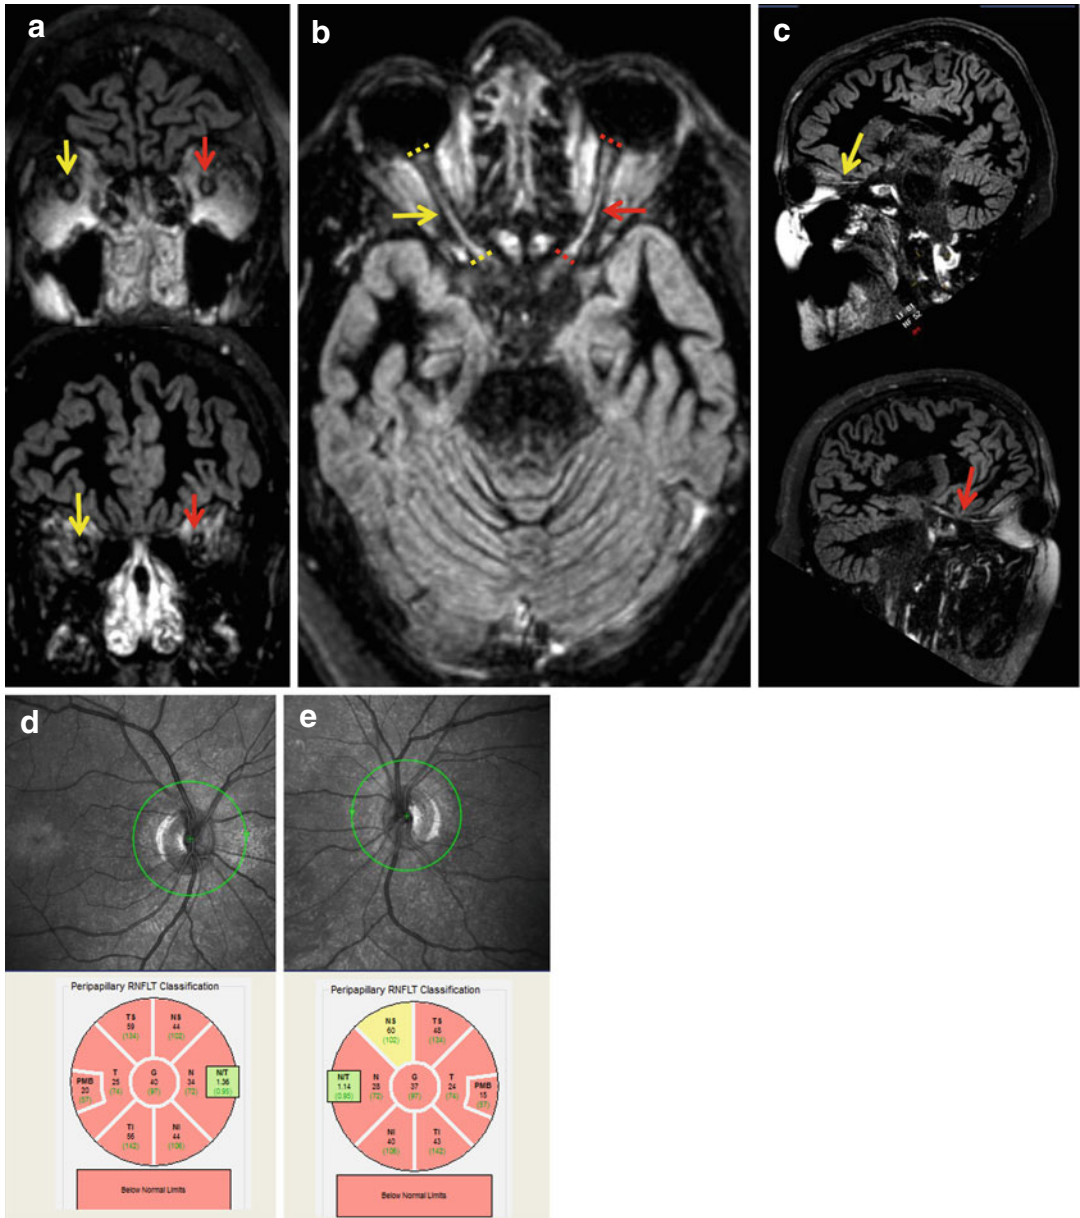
Brain 3D double inversion recovery (DIR) MRI sequence and peripapillary OCT scans of an NMOSD patient with past history of severe bilateral optic neuritis. (a) Coronal reconstruction centered on optic nerves showing bilateral T2 hyperintensities (yellow and red arrows for the right and left optic nerves, respectively) in retrobulbar (top image) and orbital (bottom image) portions. (b) Axial reconstruction showing bilateral extended T2 hyperintensities on optic nerves. The length of T2 hyperintense lesion measured between both colored dotted lines
